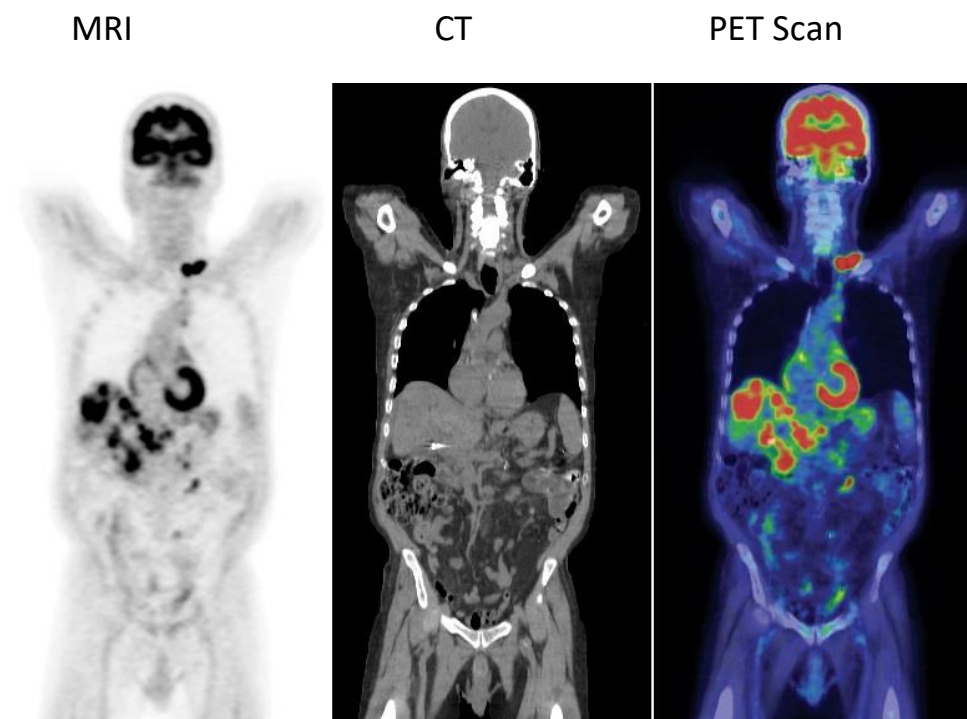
Differences between PET Scan ,CT and MRI
